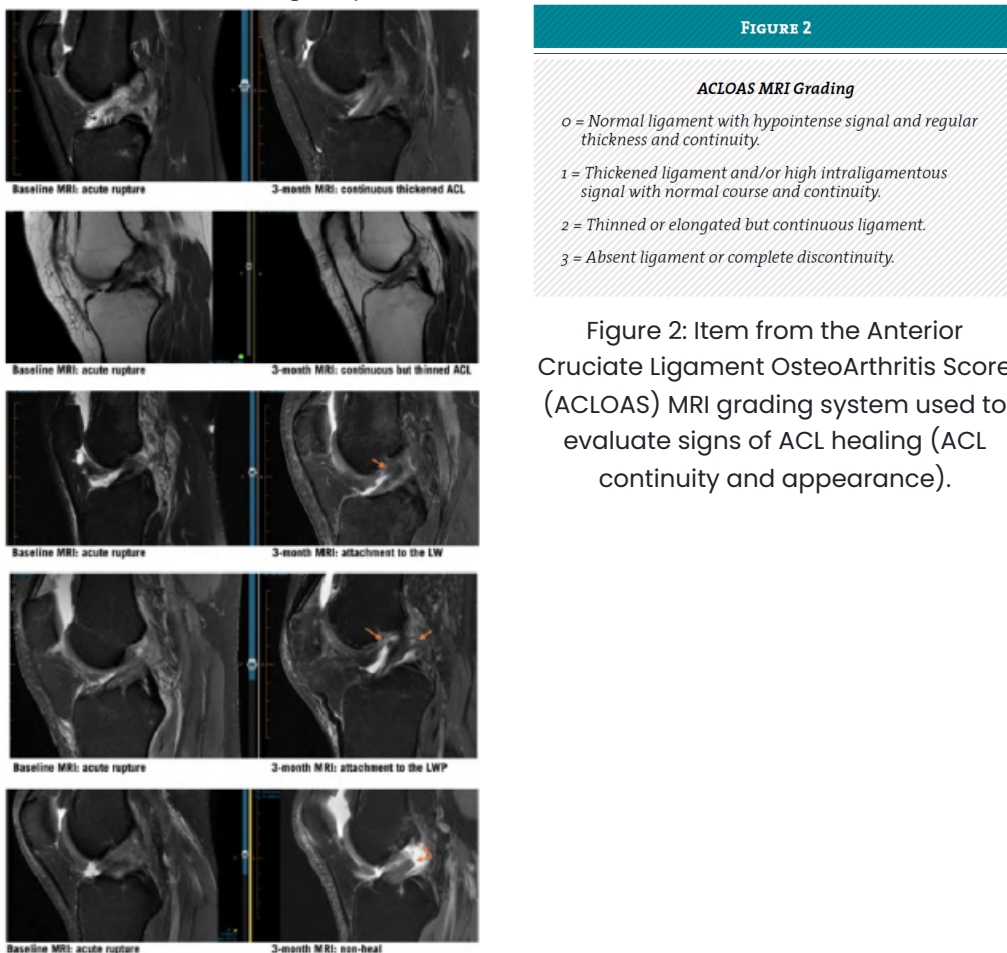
MRI images of five patients, presenting the acute ACL rupture on MRI and examples of different ACL structures on 3-month MRI. ACL, anterior cruciate ligament; LW, lateral wall; LWP, lateral wall and PCL; MRI, magnetic resonance imaging.
